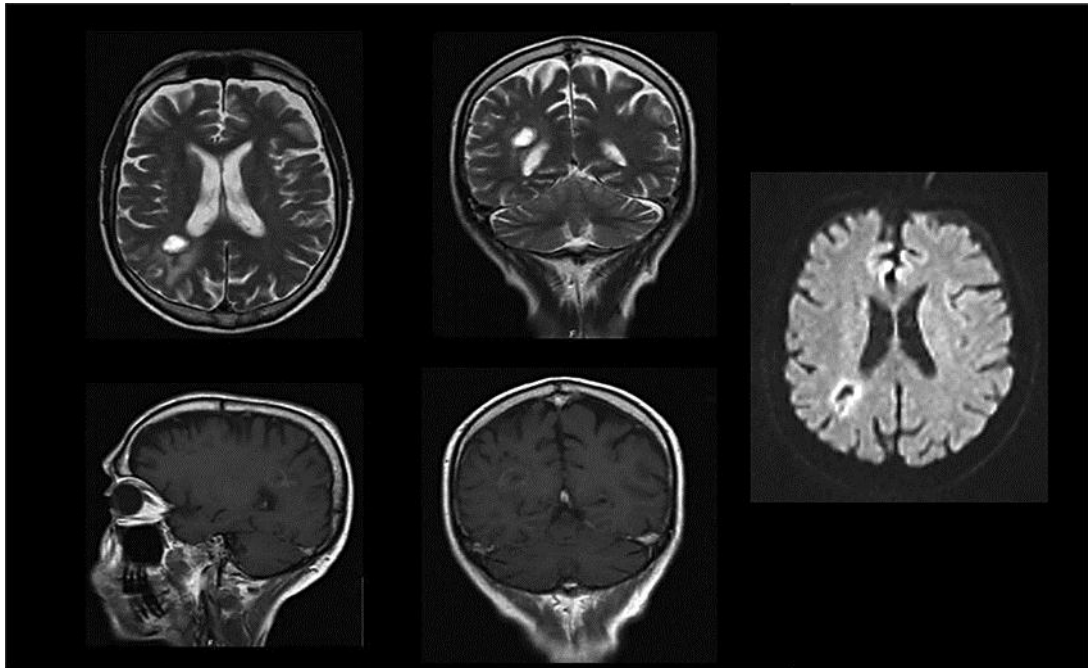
MRI of the brain revealing a single, large, right, frontoparietal, ring-enhancing lesion with high signal intensity on T2-weighted images, low signal intensity on T1-weighted images and restricted diffusion on diffusion-weighted images.
